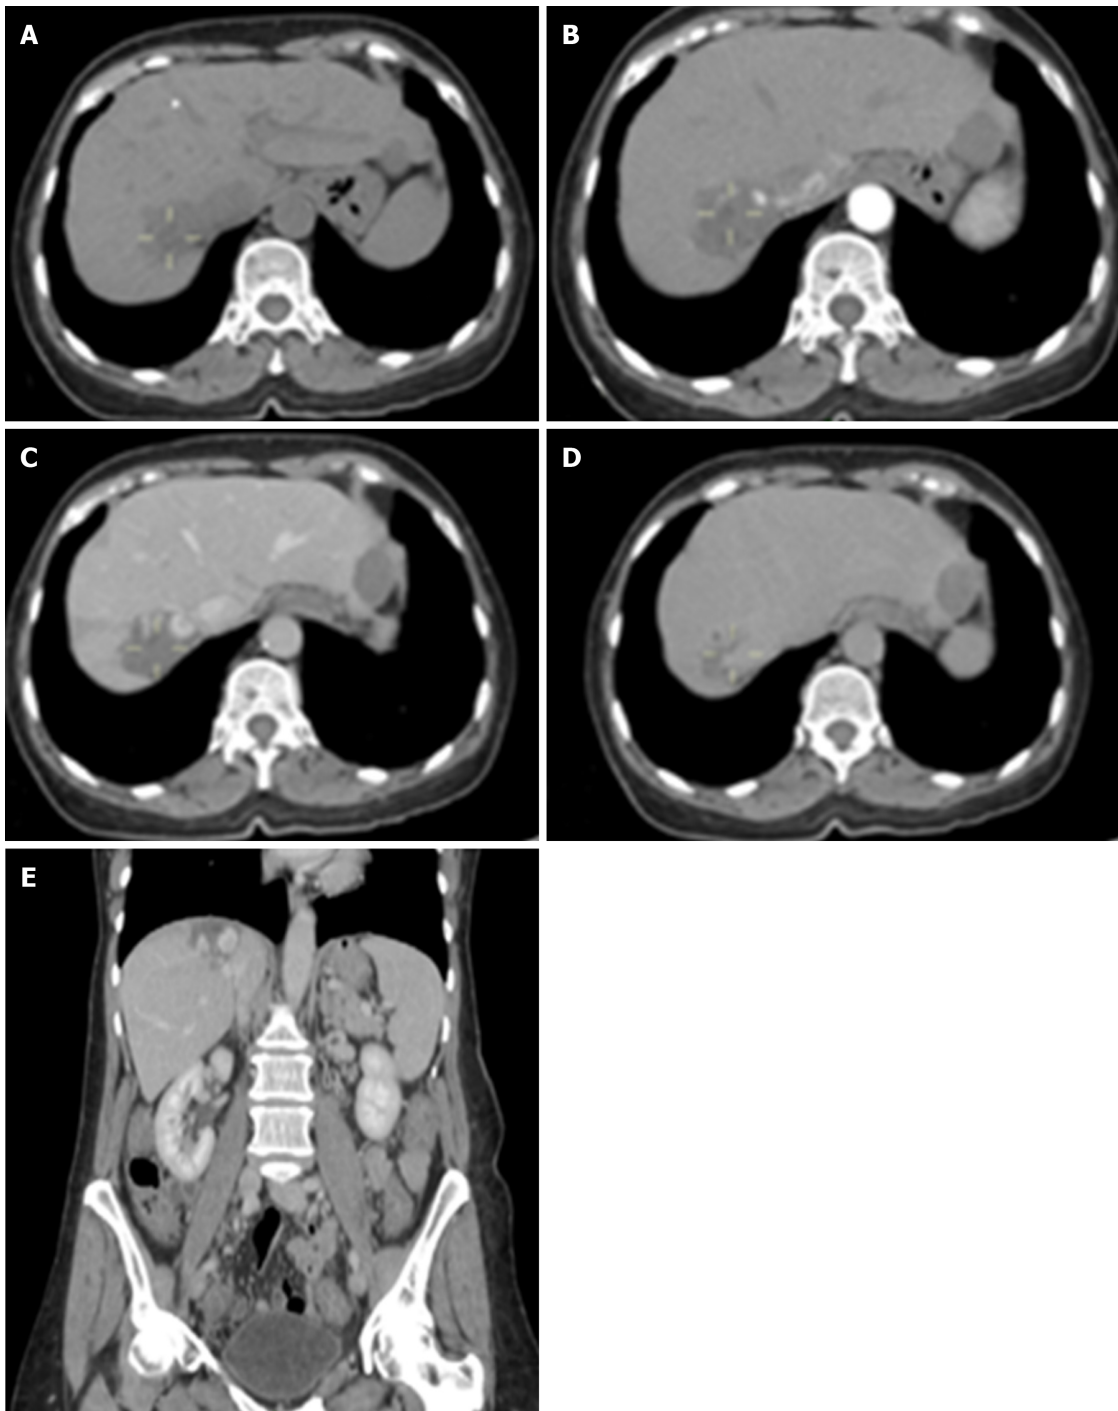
Hepatic hemangioma of 49 mm × 30 mm. A: Non-contrast phase; B: Arterial phase; C: Venous phase; D: Delayed phase; E: Coronal view of computed tomography scan (venous phase).
